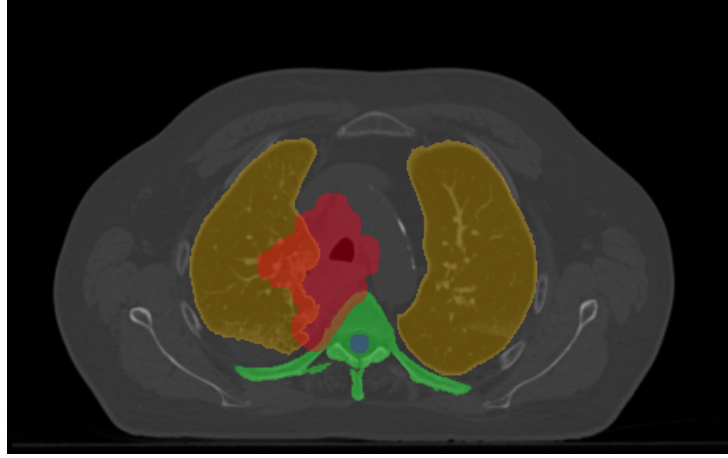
Exemple d’une image CT et de la représentation de différentes structures du patient : poumons (orange), région cible comprenant la tumeur (rouge), moelle épinière (bleu) et des os de la colonne vertébrale (vert).
